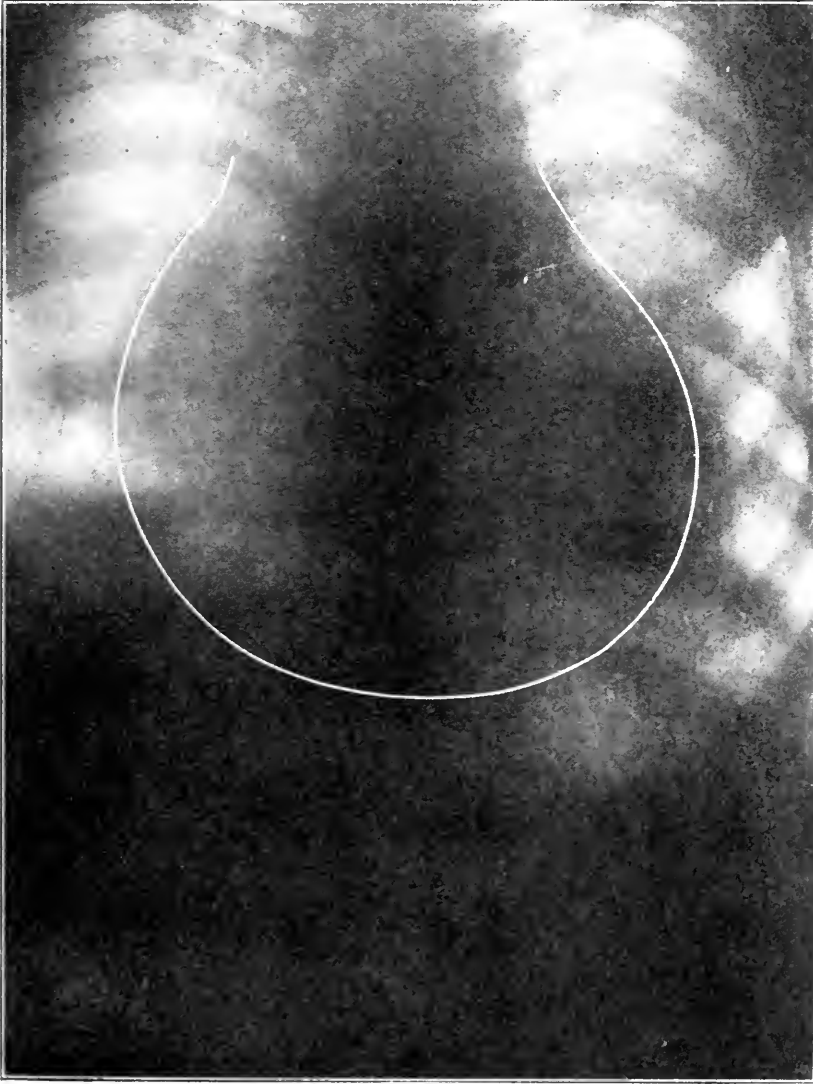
Cardiac radiograph of J. S., case I, showing enormous hypertrophy of heart at the time treatment was begun with autogenous vaccine made from the crypts of his tonsils. (Courtesy Medical Clinics of N. A.)
